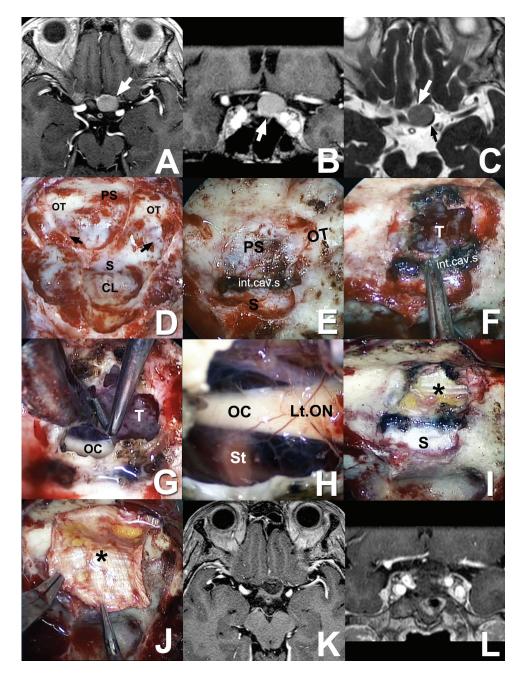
Ideal case of endoscopic transnasal surgery for tuberculum sellae meningioma in an 80-year-old woman with significant visual deterioration of the left eye. A–C: Magnetic resonance imaging (MRI,  $T_1$ -weighted image with gadolinium enhancement: A, axial section; B, coronal section,  $T_2$ -weighted image: C, axial section) showed an enhanced lesion on the tuberculum sellae (*white arrows* in A–C), compressing the left optic nerve (*black arrow* in C). D: After wide sphenoidotomy, the anatomical indexes were disclosed in the sphenoid sinus under the vision of 0 degree scope E: Skull base bone of the sella and the planum sphenoidale were removed, and the intercavernous sinus (int.cav.s) was coagulated with bipolar forceps. F: After coagulation of the dura matter, it was opened to reveal the devascularized tumor (T) on the tuberculum sellae. G, H: Under the vision of 30-degree scope, the tumor was carefully dissected and removed piece by piece along the arachnoid membrane in front of the optic chiasma (OC). After complete removal, the OC, the left optic nerve (Lt.ON), and the pituitary stalk (St) were clearly observed. I, J: Fascia lata (\*) was harvested and was placed in and out of the dural defect. The balloon catheter was inserted in the sphenoid sinus and the outlaid fascia was compressed by the inflated balloon for several days. K, L: After the surgery,  $T_1$ -weighted MRI (A, axial section; B, coronal section) with gadolinium enhancement showed total removal of the tumor, and her visual symptom completely improved. CL: clivus, OT: optic canal, PS: planum sphenoidale, S: sella turcica, *black arrows*: carotid prominence.
